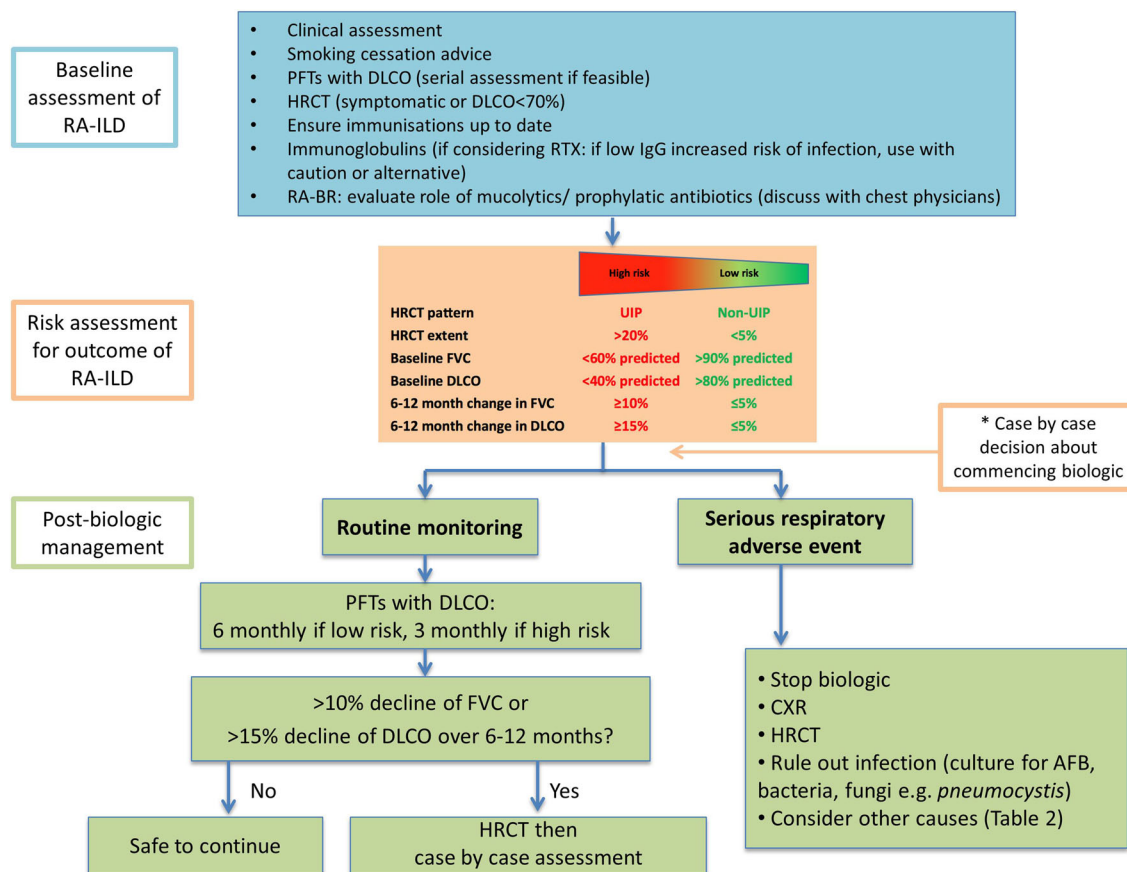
Suggested algorithm for assessment, monitoring, and management of patients with RA-ILD. *AFB* acid-fast bacilli, *DLCO* diffusion capacity of the lung for carbon monoxide, *FVC* forced vital capacity, *HRCT* high-resolution CT, *NSIP* nonspecific interstitial pneumonia, *PFTs*
